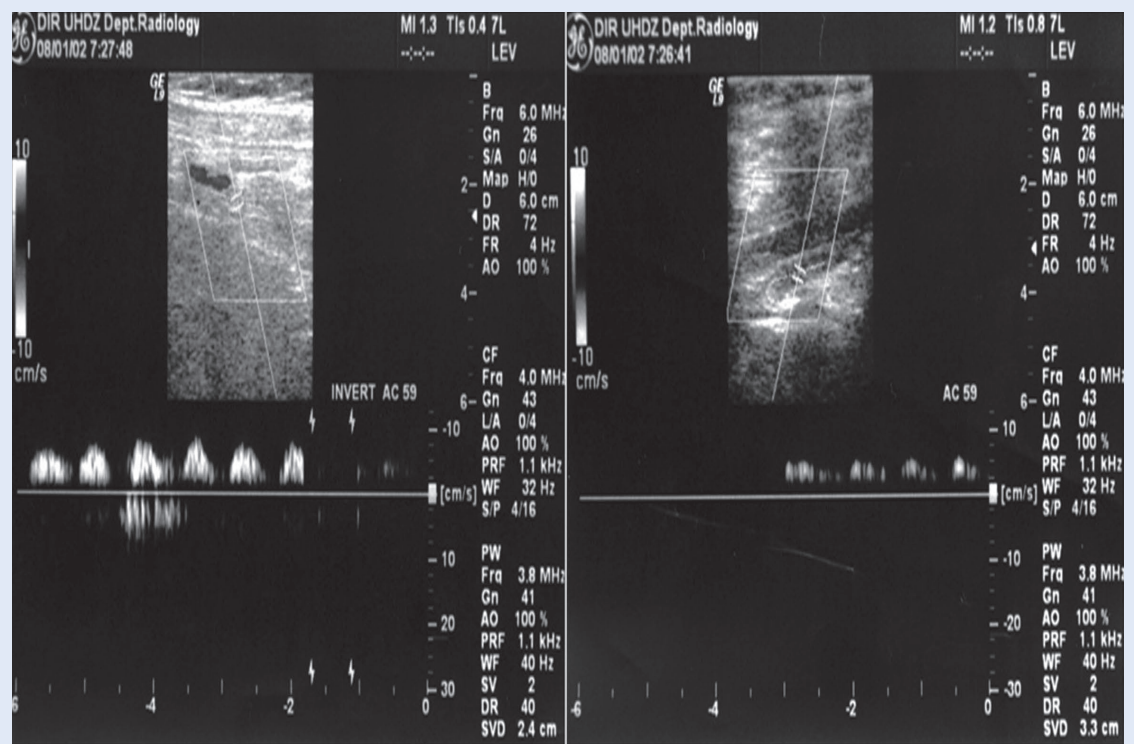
Ultrasonography duplex doppler examination: low flow velocities in both superficial femoral arteries with peak systolic velocity lower than 5 cm/s and changed spectra.
